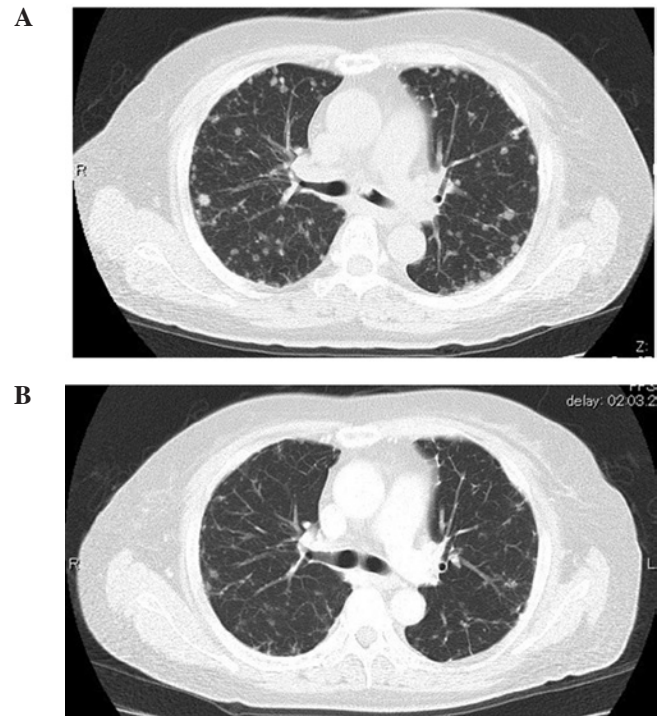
Thorax CT revealed (A) numerous nodular lesions in both lung fields; a nodular lesion was observed at the entrance to the left main bronchus prior to chemotherapy. (B) Disappearance or size reduction in some granular lesions was observed following chemotherapy. The nodular lesion observed at the entrance to the left main bronchus disappeared after chemotherapy.
